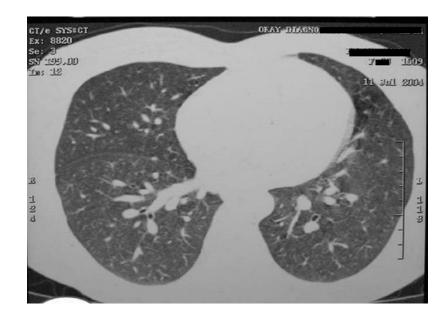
CT thorax suggestive of associated miliary TBs
